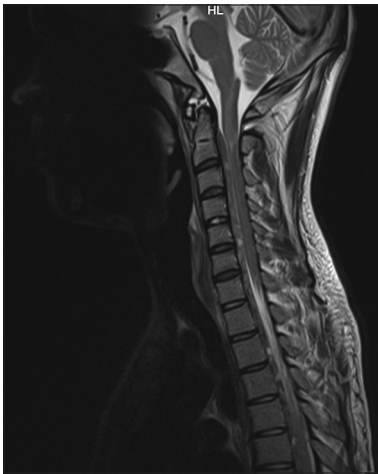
Magnetic resonance imaging cervical spine sagittal cuts showing epidural haematoma
